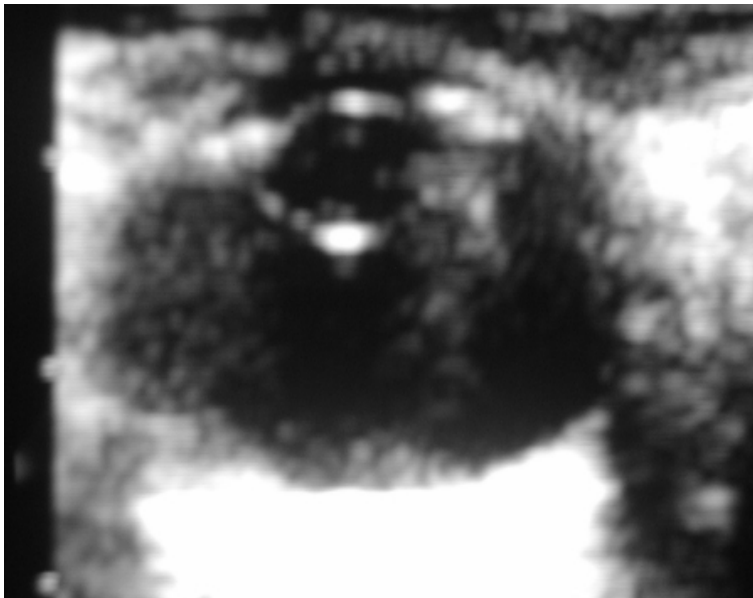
Intraocular foreign body on ultrasound scan
